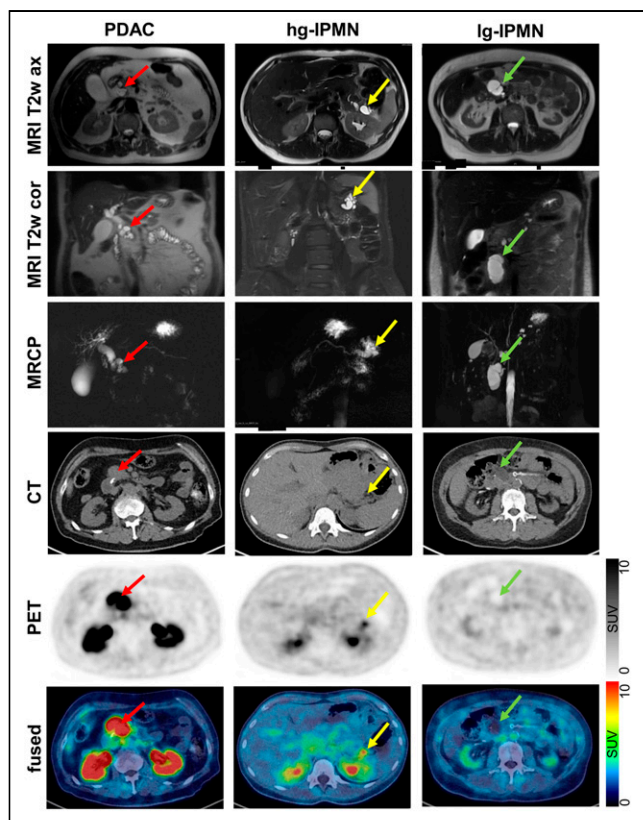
Representative axial and coronal T2-weighted MRI (MRI T2w ax and MRI T2w cor, respectively), MR cholangiopancreatography (MRCP), axial CT (CT ax), axial PET (PET ax), and fused images of a patient with hc hg-IPMN with progression into PDAC, a patient with hg-IPMN without PDAC, and patient with lg-IPMN. Red, yellow, and green arrows indicate pathologies.
